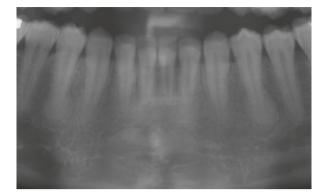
This is a cropped panoramic radiograph which shows hypercementosis on the second right-hand-side mandibular premolar and the first left-hand-side mandibular premolar. One can appreciate the presence of a lamina dura and a periodontal ligament space around the hypercementosis area in the apical third of the respective root. This is a radiograph of a 25-year-old woman. Nevertheless the author considered it was useful to show an example, since hypercementosis is not common in children and one needs to be able to differentiate from cementoblastoma or true cementoma
